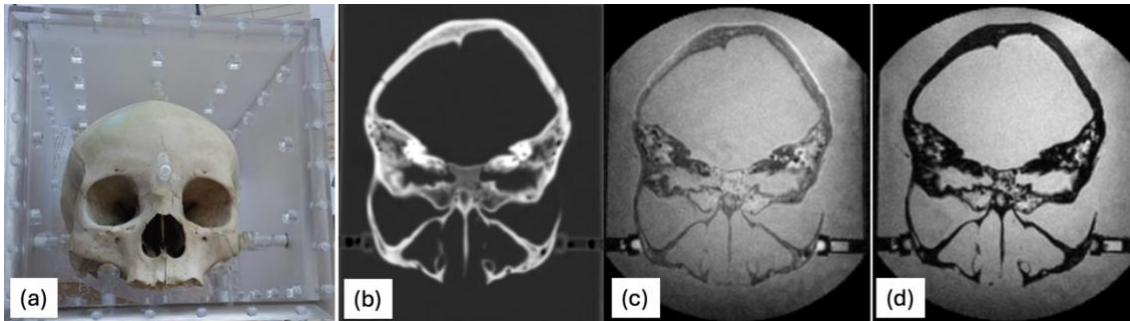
a) The human skull is held steady inside the container with posts filled with water. B) CT image, c) and d) first and second echoes of UTE, respectively. Reproduced with permission from Wiley publication (139).
